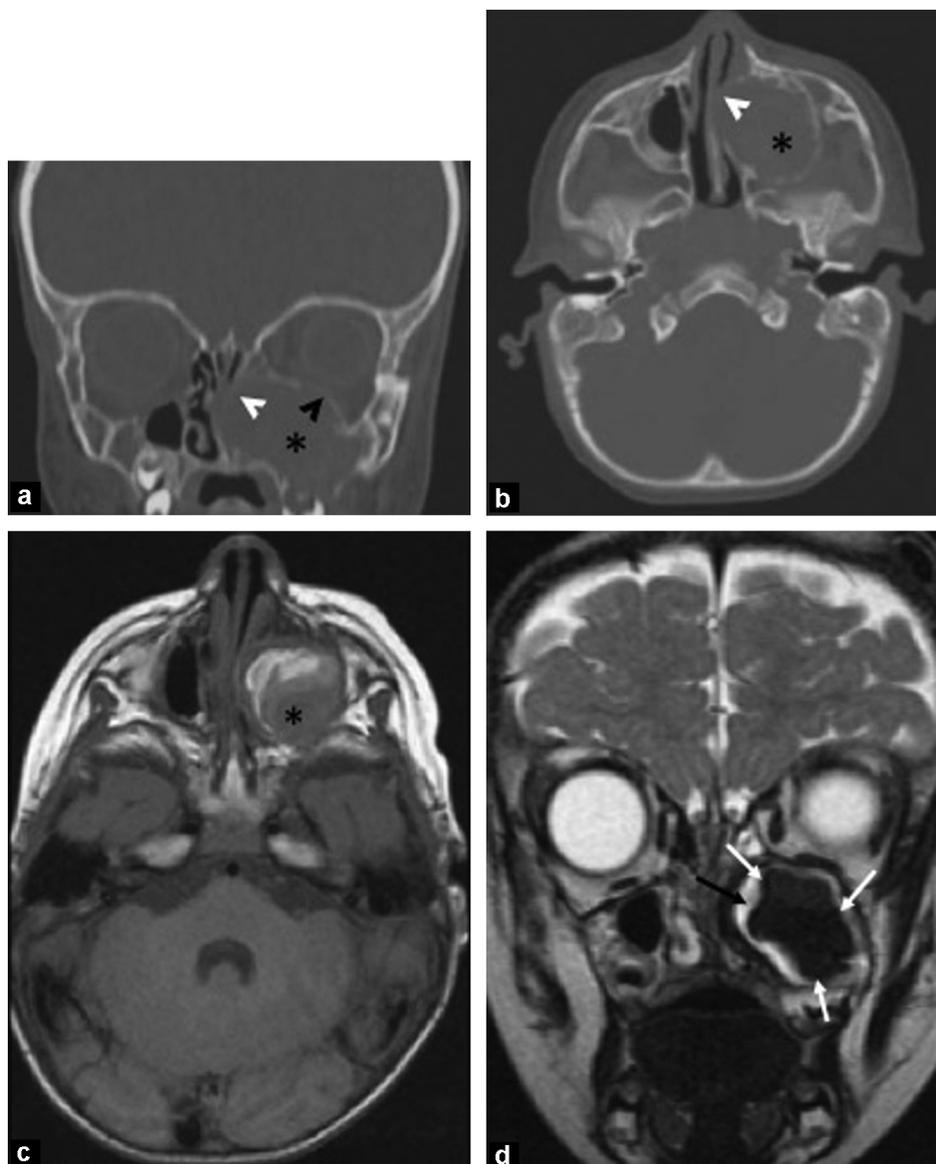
15-month-old boy with moderate hemophilia B presenting with mild left exophthalmos and forehead bruising after two minor head traumas one month before. Results of neurological examination were normal. Head CT image in the coronal (A) and transverse (B) planes using bone window show a mass extending into the left maxillary sinus (asterisk), displacing the orbital floor (black arrowhead) and the medial wall of the maxillary sinus (white arrowheads) with non-aggressive cortical scalloping of the sinus walls. T1-weighted MR image in the transverse plane (C) and T2-weighted image in the coronal plane (D) reveal organized hematoma in the left maxillary sinus that appears as a well-demarcated, heterogeneous mass (asterisk) with different signal intensities and a capsule (white arrows). The intact mucosa around the lesion (black arrow) indicates a benign process. CT performed four months and eight months after long-term prophylaxis showed a shrinking of the mass, which completely disappeared four years later (not shown).
